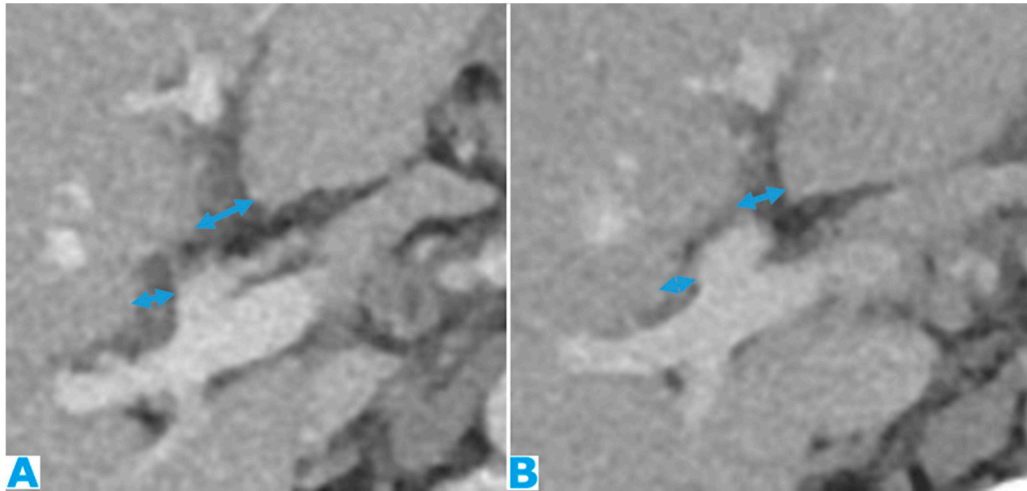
Axial CE-CT (A, current study, and B, from one year prior). PC from gastric adenocarcinoma: Subtle soft tissue mass occupying the periportal space. Observe the periportal space enlargement, more conspicuous if compared to the previous CT.
